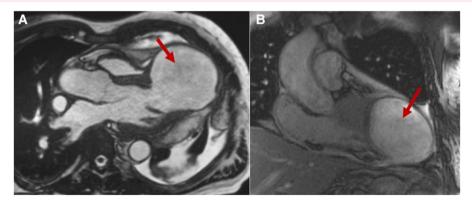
Cardiac magnetic resonance imaging three-chamber cine image in axial plane (A) and true FISP image in coronal plane (B) with large left ventricular aneurysm and concern for lack of myocardial tissue present at the apex.
